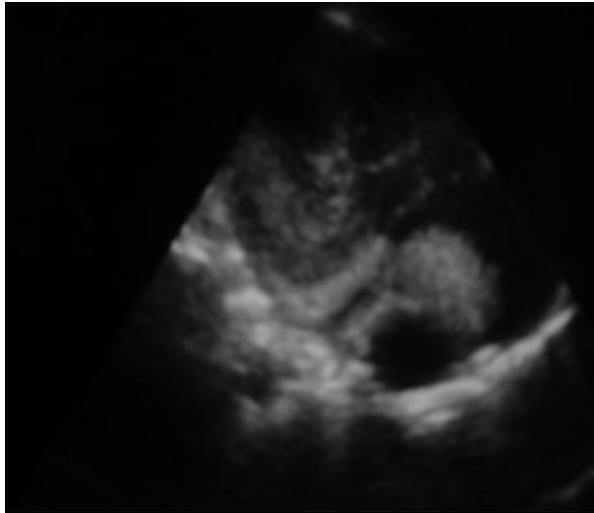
Right atrial thrombus demonstrated by echocardiography.
